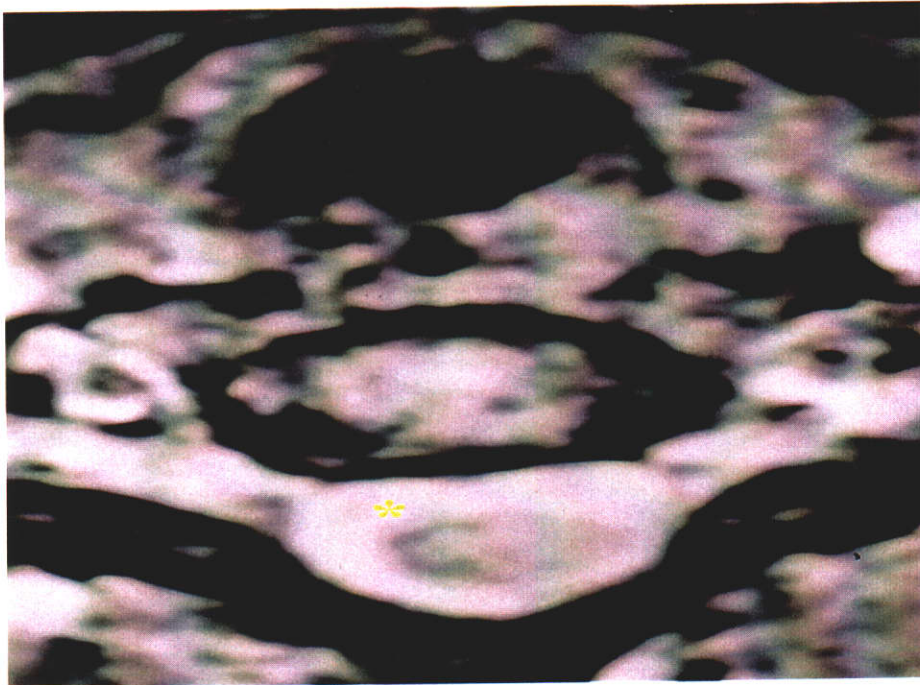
MRI showing normal arrangement of structures within the spinal canal.
